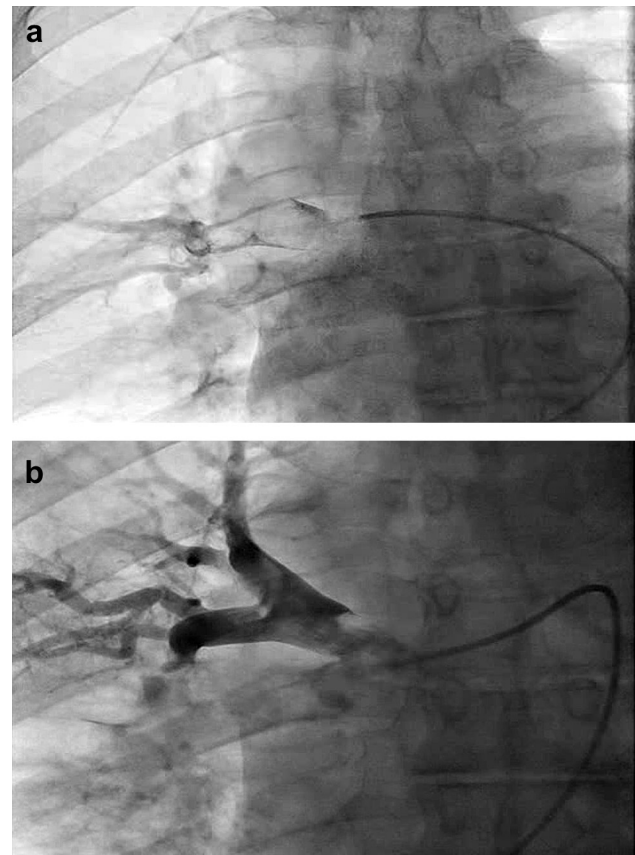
a: Pulmonary angiogram demonstrating the right main pulmonary artery with large extensive thromboemboli, involving the right middle and lower lobar arterial branches. b: Pulmonary angiogram showing patient right main pulmonary artery with adequate distal filling of the entire pulmonary vasculature after successful use of ultrasonic-accelerated catheter-directed thrombolysis (UCDT).
